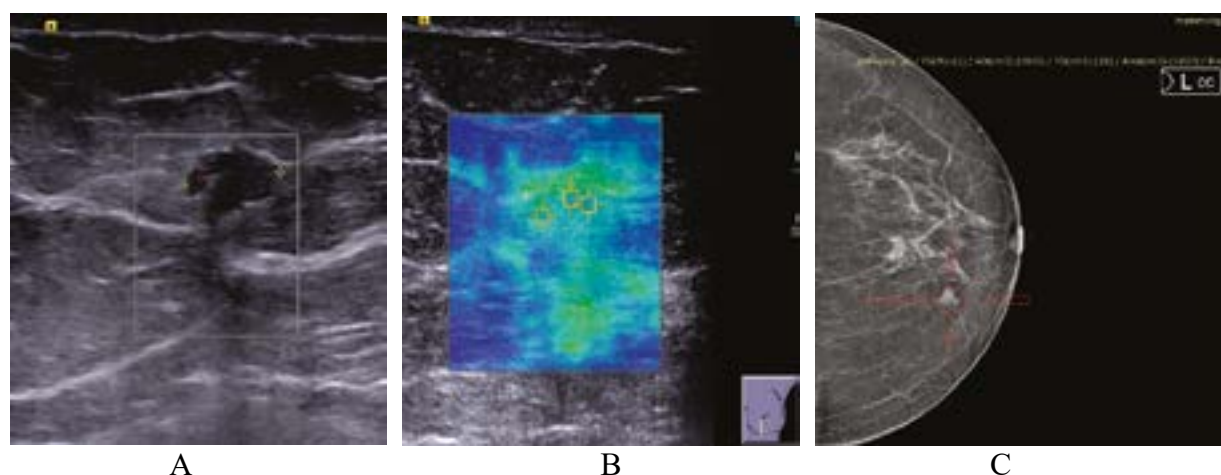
Ultrasound and mammographic signs of fibroadenoma: A – a hypoechoic mass with a clear, even contour, horizontal orientation; B – elastography: medium density formation; C – mammographic signs of fibroadenoma
